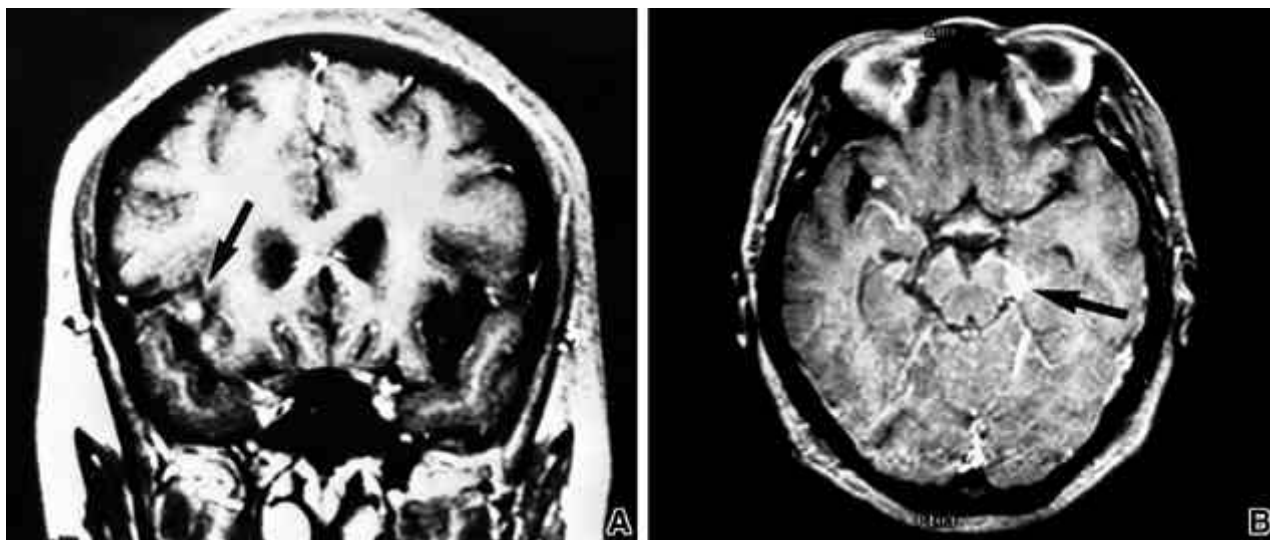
Brain MRI shows a small enhanced mass in the right temporal lobe (A, black arrow) and a few small enhanced mass in left portion of the basilar cistern (B, black arrow).
